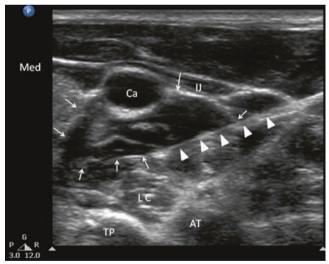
Cross section of the neck at the sixth cervical vertebral level correlating with the ultrasonographic image. (Reproduced with permission from USRA (www.usra.ca))
